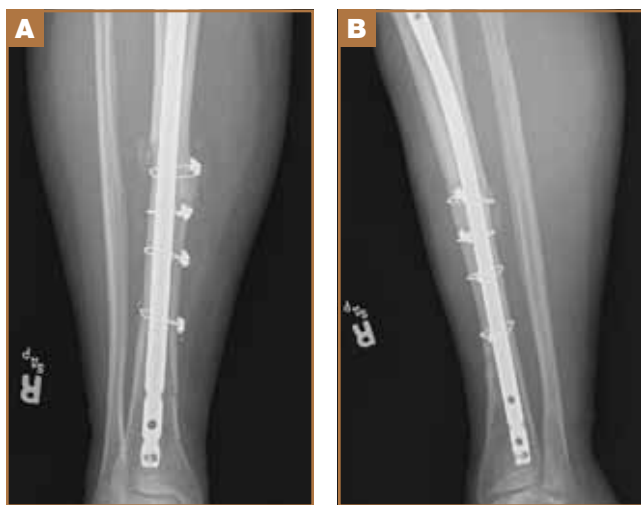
Anteroposterior (A) and lateral (B) radiographs show satisfactory reduction and anatomical rod fixation of revised wedge segmental fracture.
